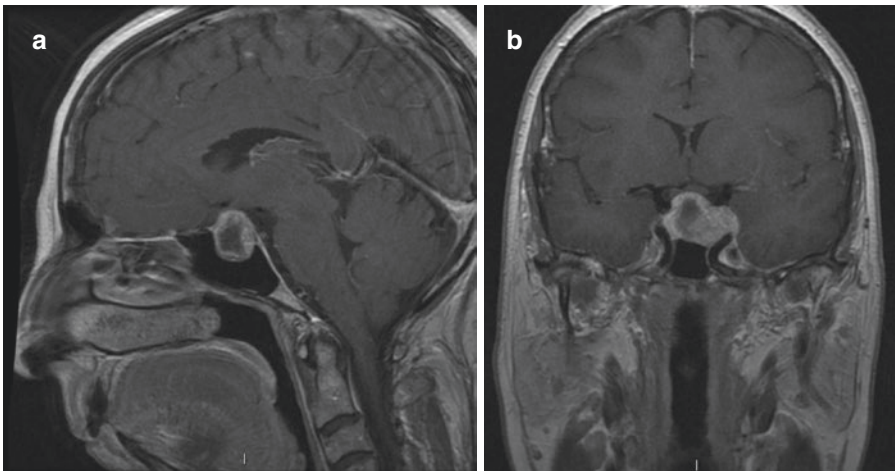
Sagittal and coronal T1 MRI with gadolinium of pituitary macroadenoma
